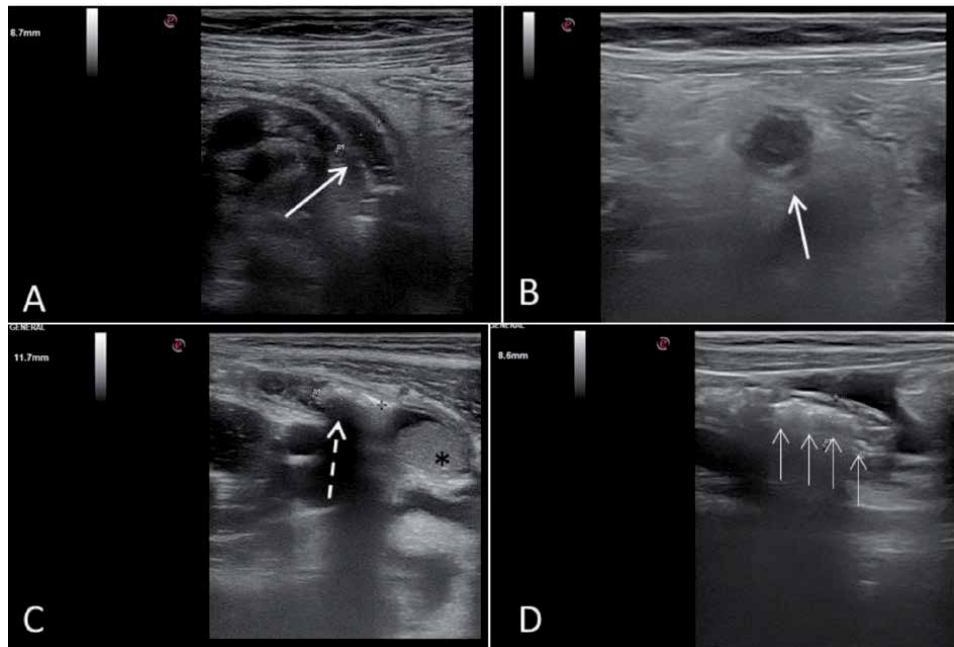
Three different cases with acute appendicitis. Ultrasound images of an 8-year-old boy demonstrate longitudinal (A) and transverse (B) section of inflamed appendix (arrow) with a diameter of 8.7 mm, and hyperechoic inflamed periappendiceal fat tissue. Ultrasound image of a 9-year-old boy (C) shows appendicolith (dashed arrow) within the appendix lumen, fluid level (asterisk) and dilatation distal to the obstruction. Ultrasound image of a 5-year-old girl (D) demonstrates inflamed appendix with a diameter of 8.6 mm and periappendiceal reactive fluid. Despite the inflammation, lumen is filled with air seen as echogenicity with dirty posterior shadow (thin arrows).
